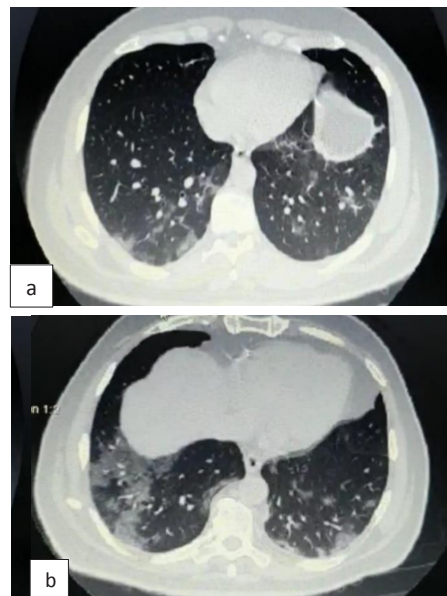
Two examples of CT scan of bilateral peripheral patches of ground glass involvement (lung opacity that does not obscure vascular marking) either indicating 0-4 days/ alveoli not full of inflammatory exudate, in our study GGO comprises 34% (17/50 patients) of the whole study, 35.7% of the females and 31.8% of the males [a- minimal, b- mild]
